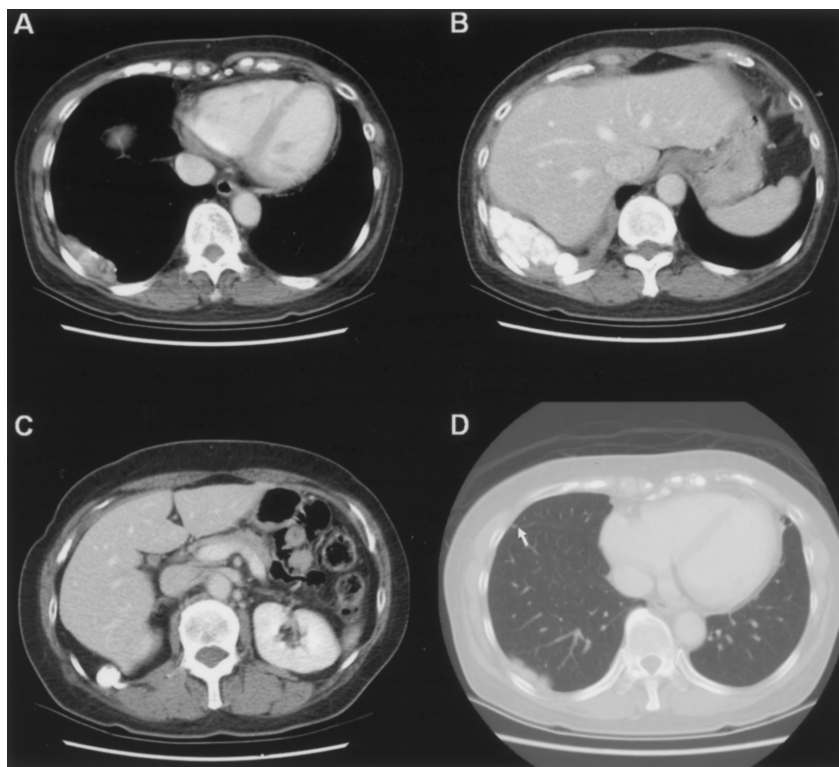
Chest computed tomography in the mediastinal window. (A) An 8-cm, contrast-enhanced pleural mass located above the right costophrenic angle, with (B) central calcification and thickened adjacent pleura, and (C) an equivocal connection to the 12th rib. (D) In the lung window, a tiny nodule in the right middle lung can be seen (arrow).
